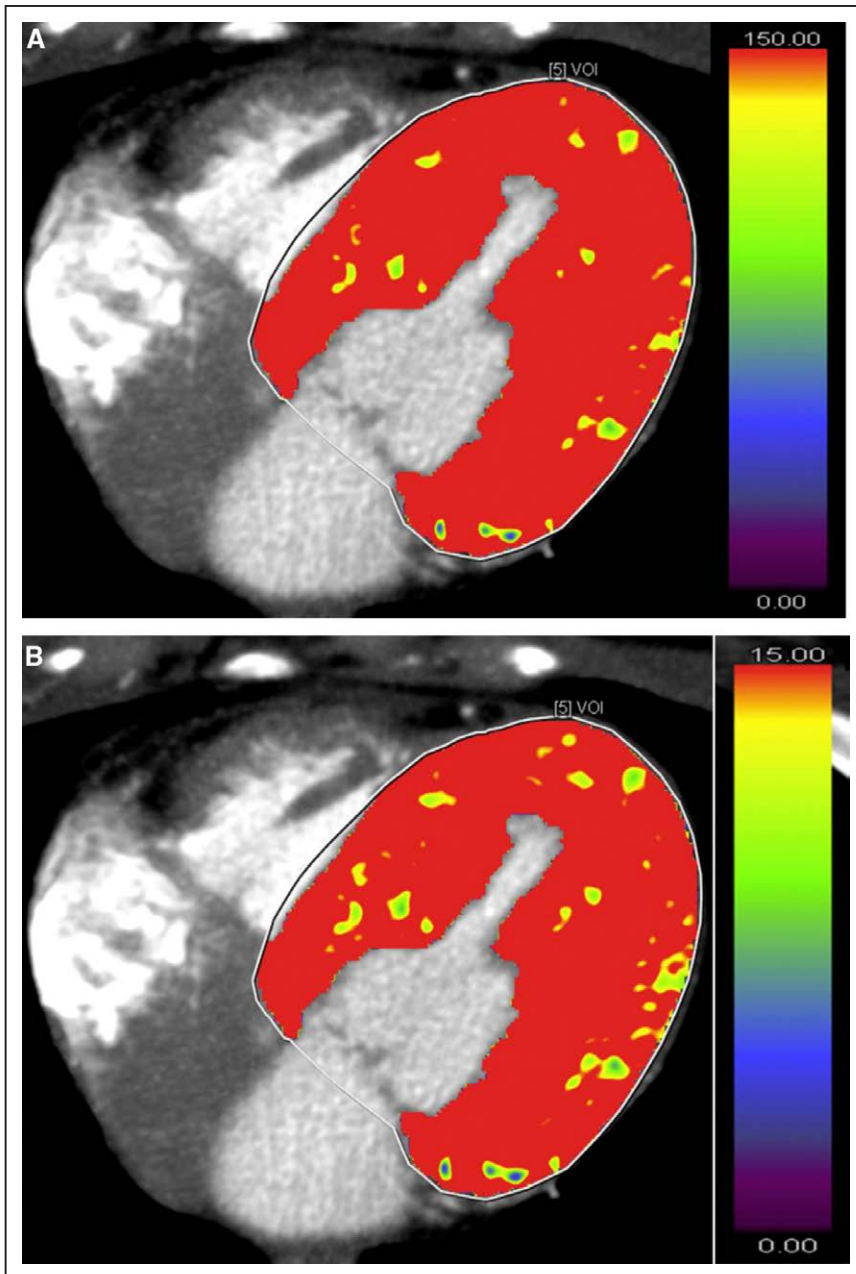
Computed tomography (CT) perfusion imaging of a patient who underwent dynamic contrast CT imaging for suspected coronary artery disease. No visual perfusion defect was detected. A and B, The color maps for myocardial blood flow and myocardial blood volume, respectively. Global left ventricular myocardial blood flow and volume were 157.7 mL/100 mL/min and 19.3 mL/100 mL, respectively. Adapted from Vliegenthart et al⁵¹ with permission of the publisher. Copyright ©2016, Society of Cardiovascular Computed Tomography.
